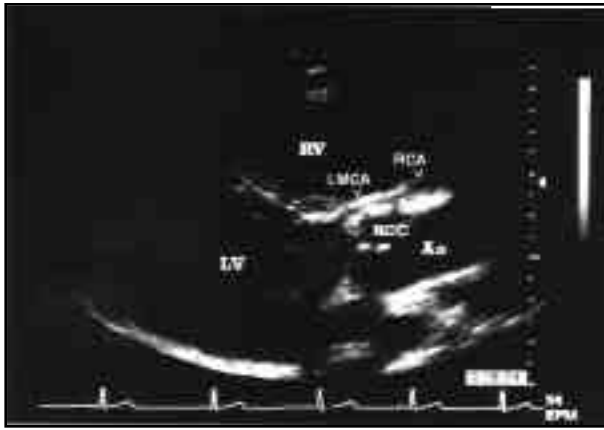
(A) Parasternal long axis view through the aortic root in a boy with anomalous left main coronary artery (LMCA) with an intramural segment of the LMCA giving the double border appearance of the aortic wall (arrowhead). Seen is a single ostium with an origin from the right coronary cusp. Right coronary artery=RCA, aorta=Ao, left ventricle=LV, right ventricle=RV.
